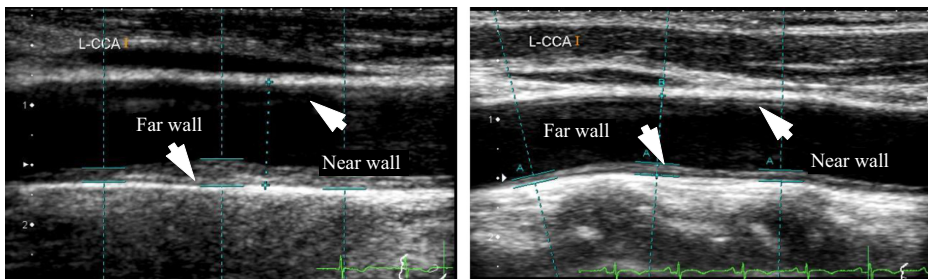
Sample raw images of B-mode ultrasound corresponding to high risk and low risk.
